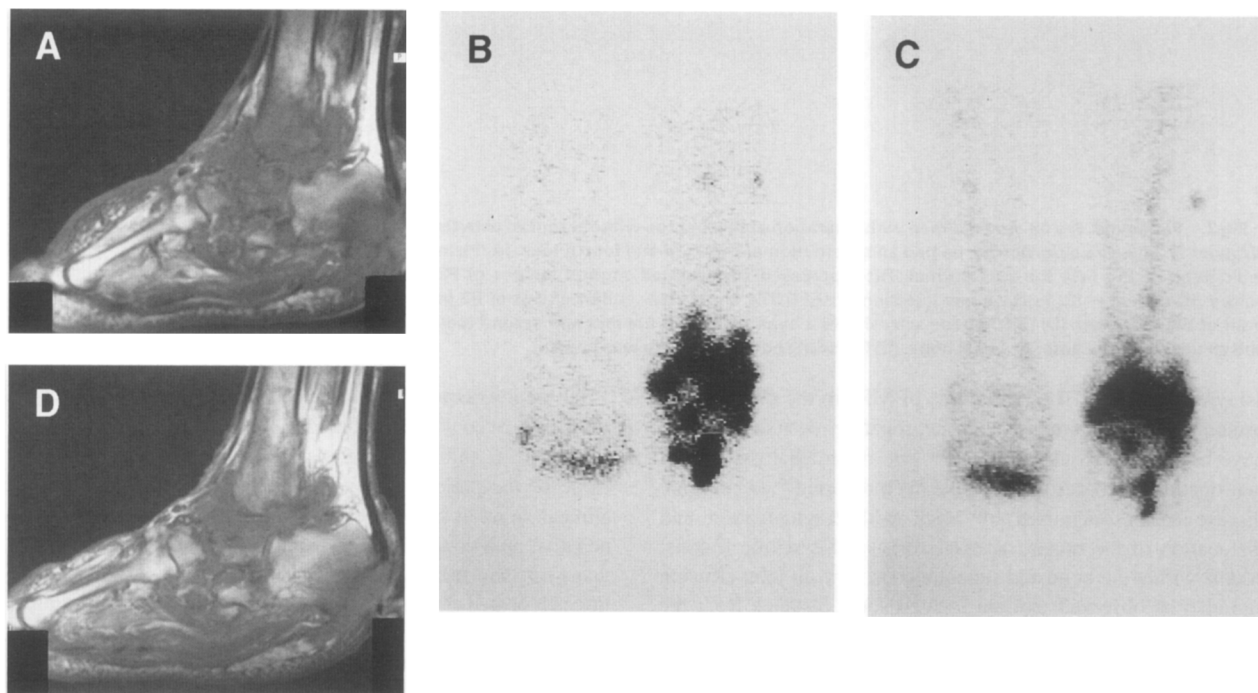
Follow-up evaluation of patient no. 6, a 59-year-old woman with Charcot's joint disease with foot ulcer (Wagner 3). Before treatment, (a) sagittal T1-weighted MRI shows thickening of soft tissue of the talus with a large low-signal-intensity area within the posterior part of the calcaneus and the tibia. Marked tibiotalar arthropathy is also present with widening of the joint corresponding to fluid effusion. Combined RI including HDP (b) and GN (c) shows marked increased uptake of the foot. Three months after antibiotic therapy, (d) sagittal T1-weighted image shows that low-signal-intensity area within the calcaneus and tibia decreased in size. Tibiotalar arthropathy was unchanged. GN scan was negative without uptake.
